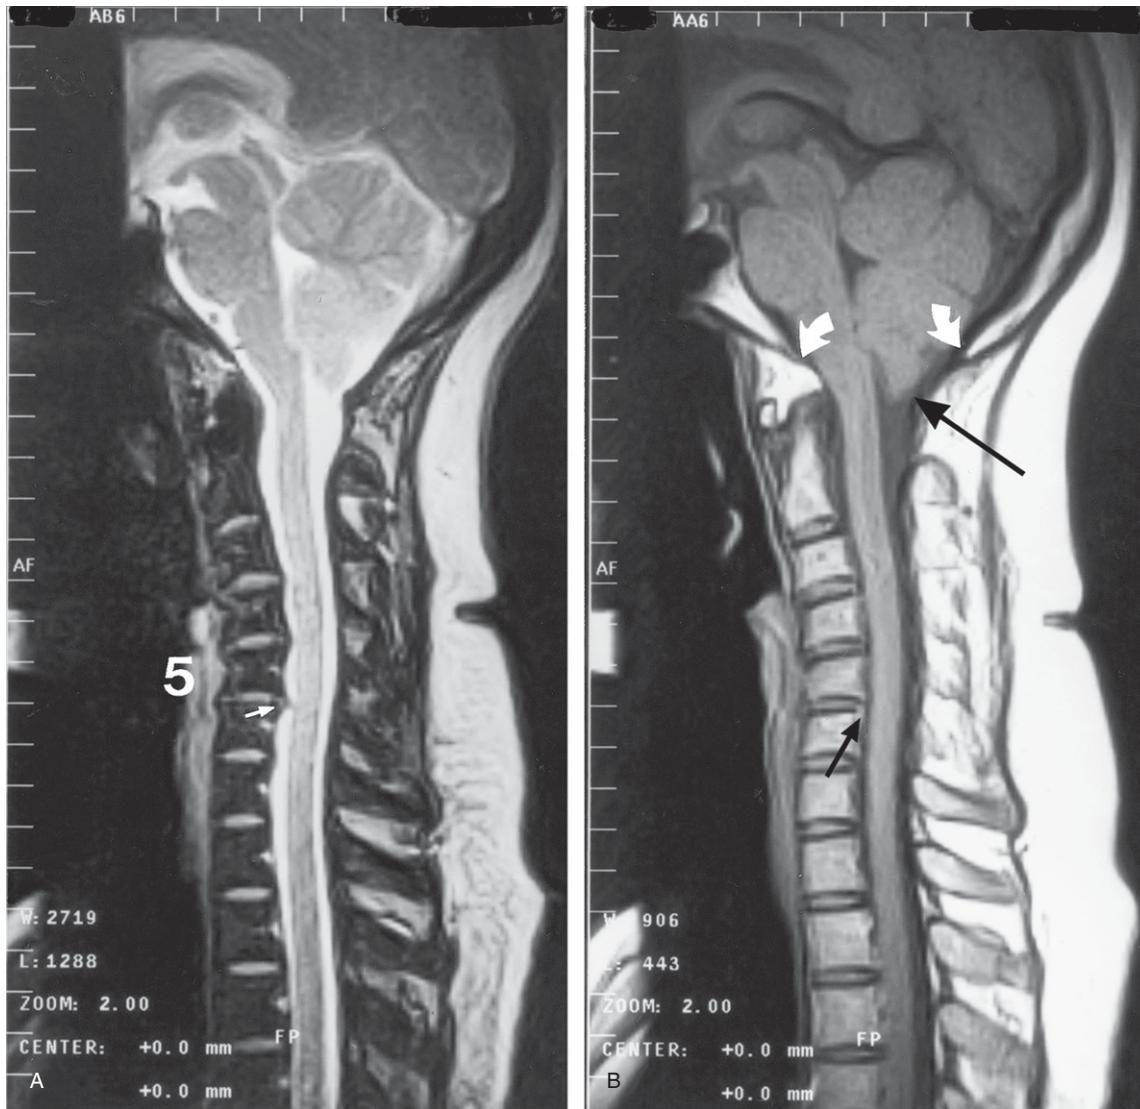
(A) Cervical spine MRI sagittal T2-weighted image showing the disc protrusion at the C5–6 level (small white arrow) and loss of the normal cervical lordosis with a mild kyphosis at the C5 level. (B) Cervical spine MRI sagittal T1-weighted image showing loss of the normal cervical lordosis with a mild kyphosis at the C5 level and disc material at the C5–6 level posteriorly (small black arrow). The cerebellar tonsil ectopia is seen more clearly on the T1-weighted image and the anterior and posterior margins of the foramen magnum are shown by the short white curved arrows. Note the cerebellar tonsil projecting below the foramen magnum (large black arrow); this woman had a mild form of Chiari I malformation.
